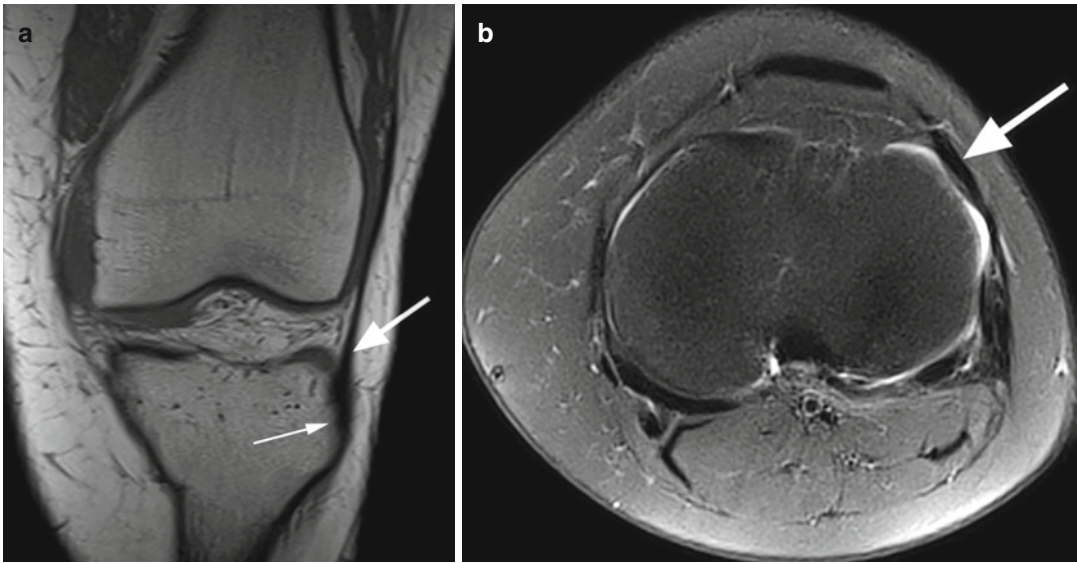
Iliotibial band in a 27 year old female. Coronal T1-weighted image (a) and axial proton-density (PD) fat-suppressed image (b) show the distal iliotibial band (large
